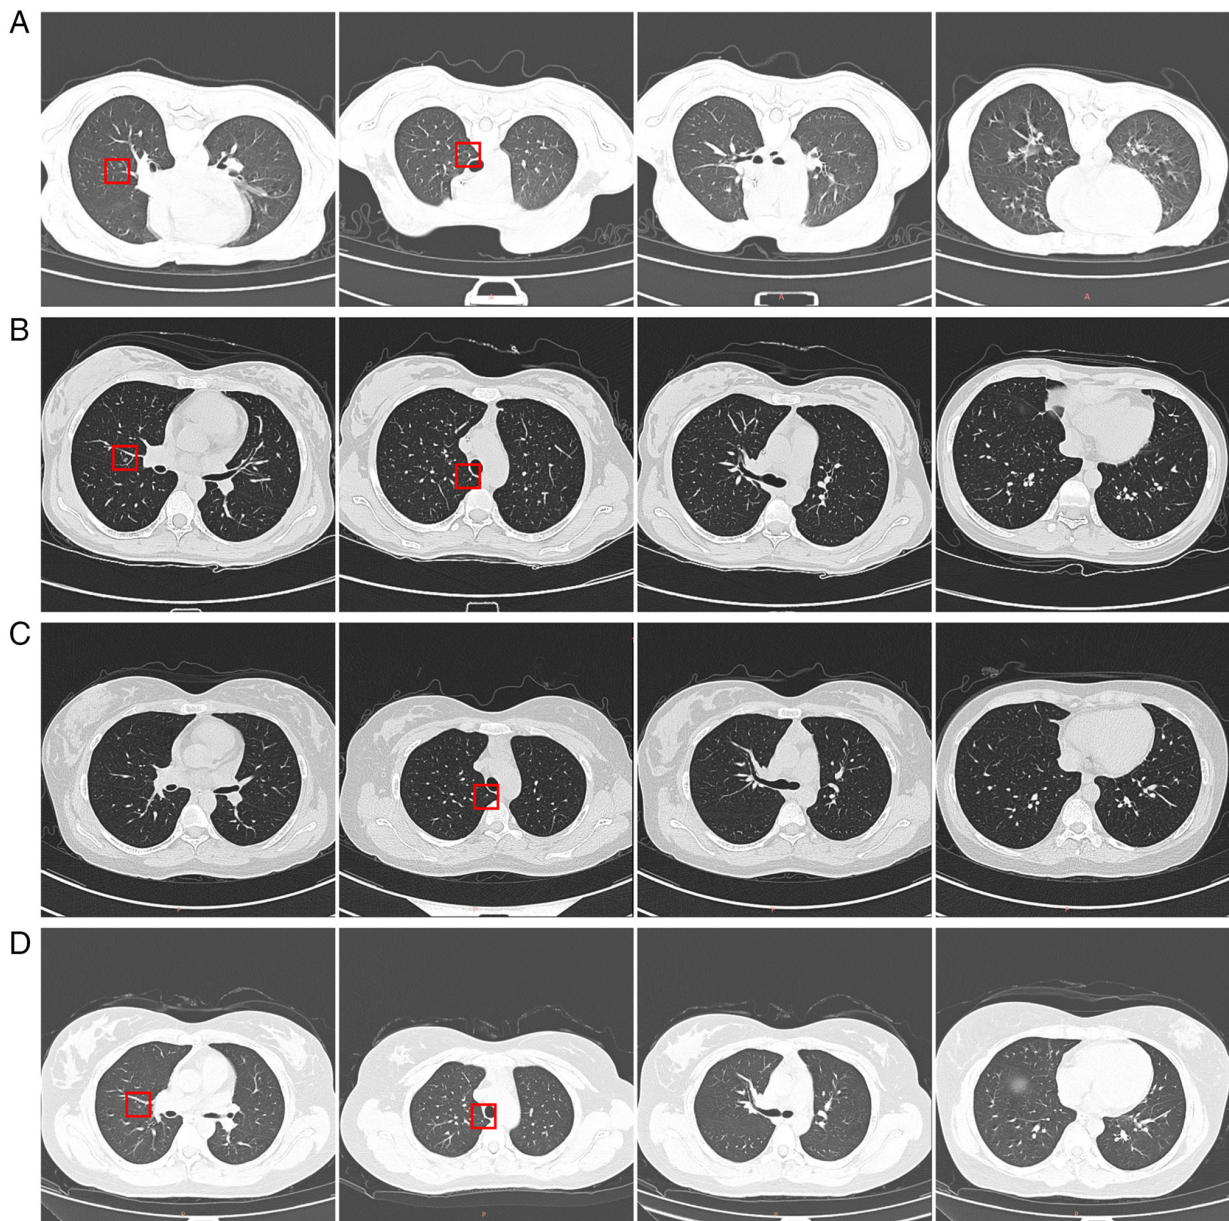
Lung CT. (A) Chest CT performed after receiving 2 cycles of anlotinib, envafolimab and gemcitabine combined with docetaxel chemotherapy in November 2022. The four panels show representative axial slices at different levels of the lungs. Red boxes highlight the target pulmonary nodule for longitudinal follow-up. Compared with the chest CT performed in September 2022, partial pulmonary lesions visible at baseline had resolved, while the marked target lesion remained observable. The maximum diameter of this target nodule is 4 mm. The nodule is composed of predominantly solid and ground-glass components. (B) Preoperative chest CT performed in June 2023. The four panels show axial slices at comparable levels to prior scans. Red boxes mark the previously noted target pulmonary lesion. Compared with the November 2022 chest CT, the nodule maintained stable maximum diameter of 4 mm and unaltered morphology consisting of solid and ground-glass components. (C) Early follow-up chest CT after completion of main-course treatment, during anlotinib targeted maintenance monotherapy, performed in June 2024. The four panels show axial slices at comparable levels to prior scans. Red boxes highlight the previously identified target pulmonary nodule. The lesion demonstrated sustained stability under maintenance therapy. (D) Later follow-up chest CT under continued anlotinib maintenance therapy, performed in March 2025. The four panels show follow-up axial slices at different lung levels. Red boxes highlight the previously identified target pulmonary nodule. The target lesion remained stable without obvious progression or regression.
